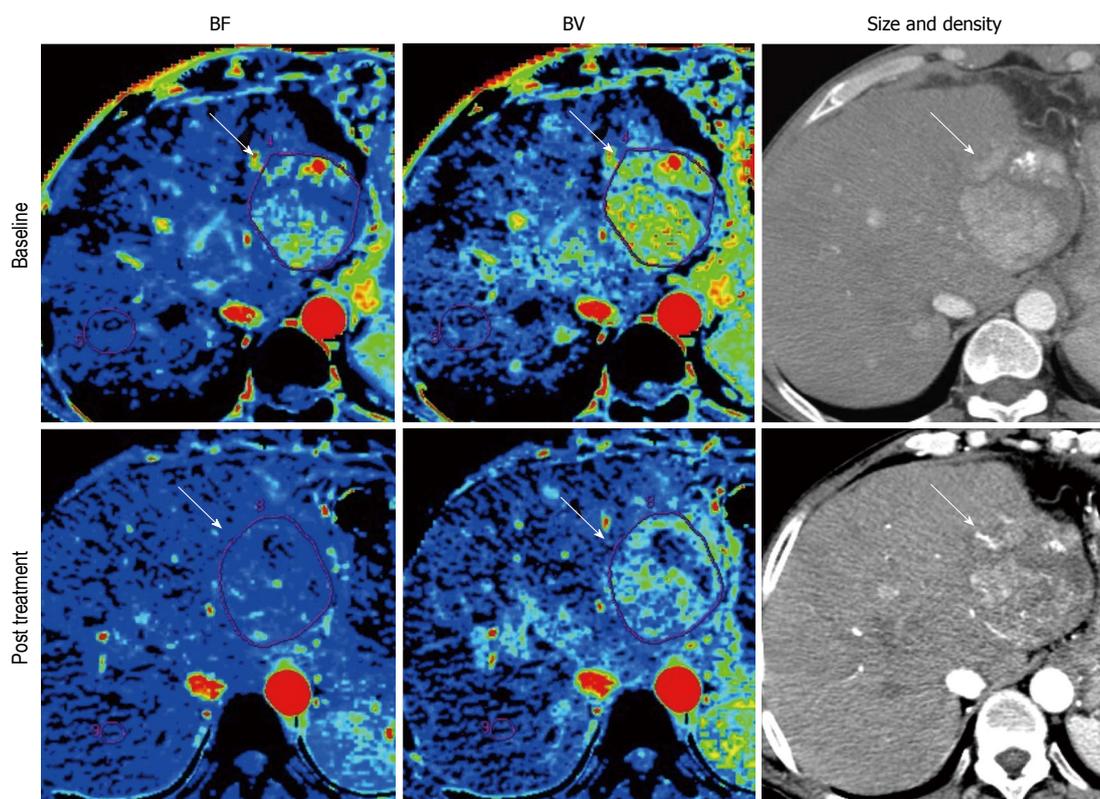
Perfusion maps of 53-year-old man with hepatocellular carcinoma. Parameters measure by perfusion computed tomography showed substantial changes in comparison with tumor size and density at only 2 wk after antiangiogenic treatment. Blood flow (BF), blood volume (BV) were -75.5% and -59.5%. On the other hand, those of size and density were not so obvious (-3.0% and -18.1%).
